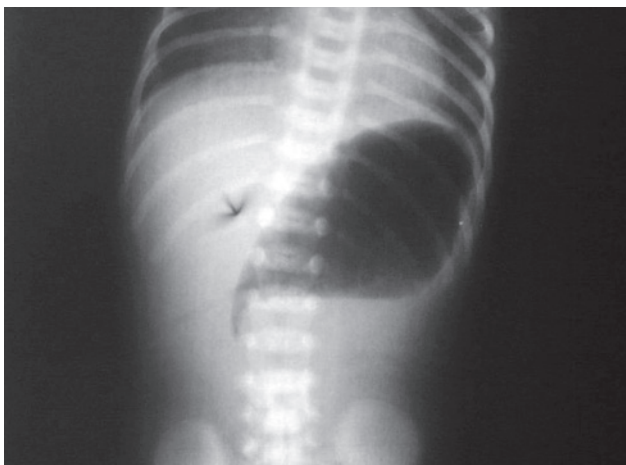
Abdominal X-ray of Case 1 shows large gastric air-fluid with lack of air distally.
